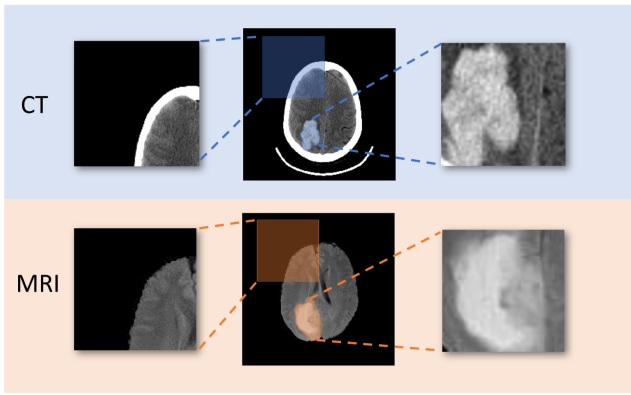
The difference between the source domain and target domain (MRI vs. CT): the manifestations of different diseases (glioma vs. cerebral hemorrhage) and the presence of the skull. We can see a noticeable difference from the enlarged part in this figure. The bright circular stripes in CT are CT head holders.
